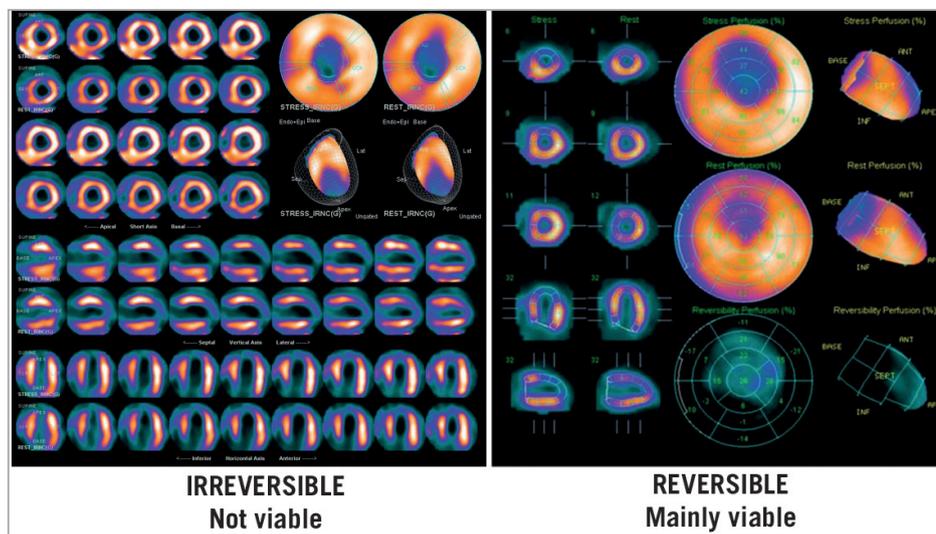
SPECT stress/rest perfusion imaging showing absence of ischaemia and viability (left panel) or presence of inducible ischaemia and viability (right panel) in two patients with LV dysfunction and left anterior descending coronary disease. LV: left ventricle; SPECT: single photon emission computed tomography
